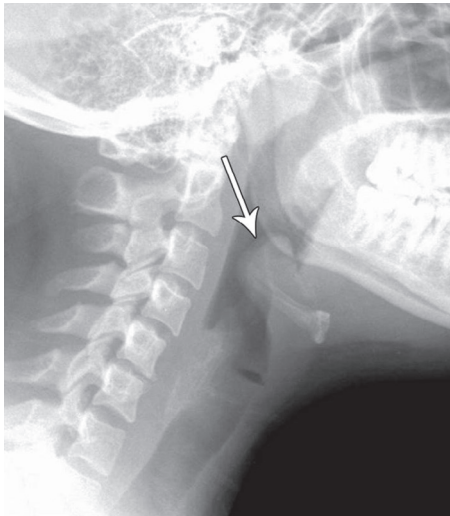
Soft tissue lateral neck x-ray demonstrating thumb sign or widening of the epiglottis silhouette (arrow).
